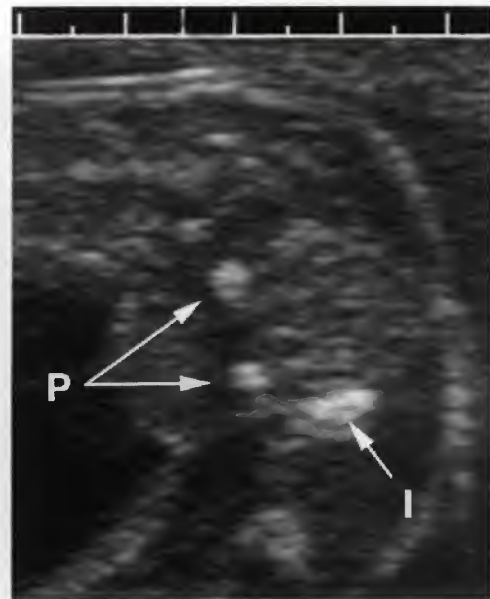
Transverse axial sonograms, sacral spine, same fetus in prone (A) and decubitus (B) positions. The posterior arch (POC) anatomy is seen well in either position. (From Filly RA, Simpson GF, Linkowski G: *Fetal spine morphology and maturation during the second trimester: Sonographic evaluation.* *J Ultrasound Med* 6:631, 1987.)
